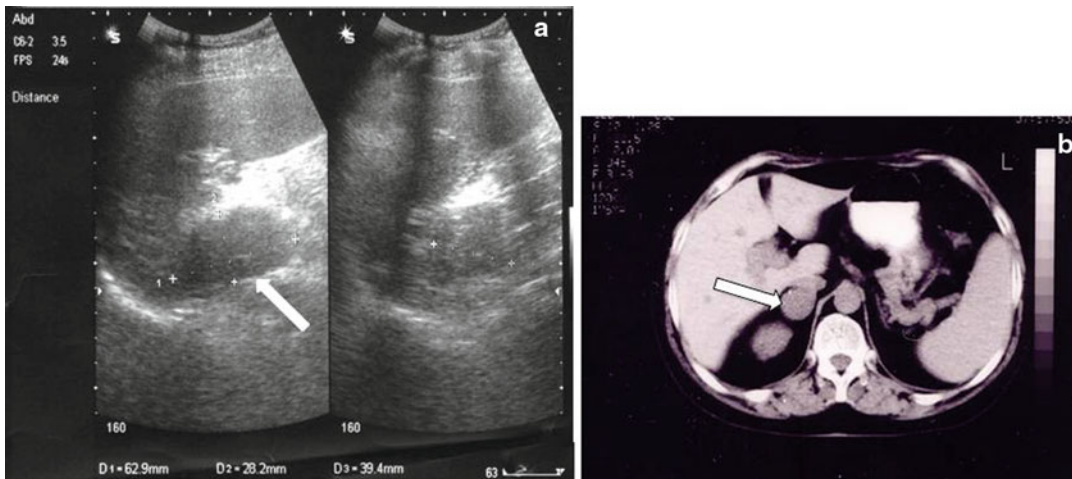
(a) Abdominal US shows a heterogeneous hypoechoic left adrenal ganglioneuroma measuring $63 \times 40 \times 28$ mm (*arrow*), (b) CT scan shows 30×35 mm
